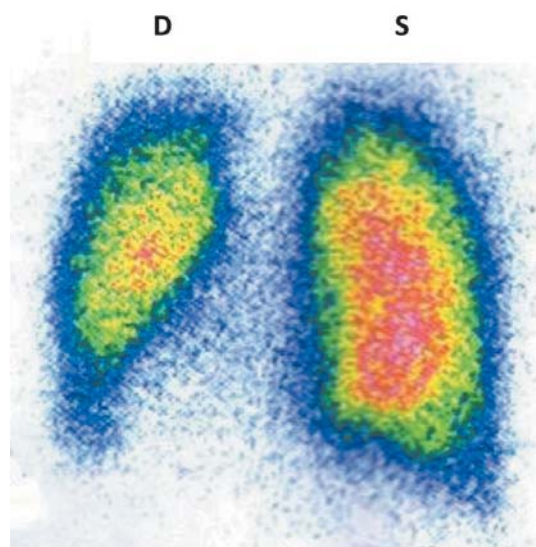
Pulmonary (perfusion) scintigraphy of the *patient C.* performed in April, 2012. Diffuse decrease of pulmonary perfusion was determined in the lung located in the right hemithorax, especially in projection of the lower lobe. Dextrocardia
